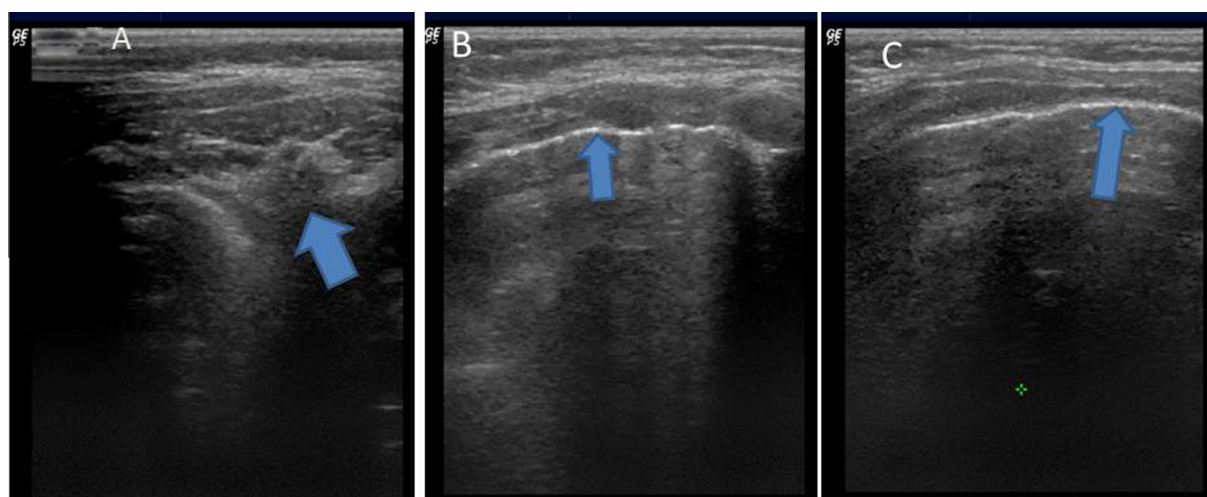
Representing the lung ultrasound of 9 months-old infant with severe bronchiolitis and the follow-up findings: On A – There is triangular shaped hypoechoic area on the Rt. lung with findings corresponding to the subpleural area of consolidation (arrow). B – On follow-up of this infant after 8 days, resolution of the subpleural consolidation is noted but still, there is residual pleural line irregularities (arrow). C – On follow-up after 12 days, it revealed near complete resolution of the above described findings and even the pleural line appeared nearly normal.
